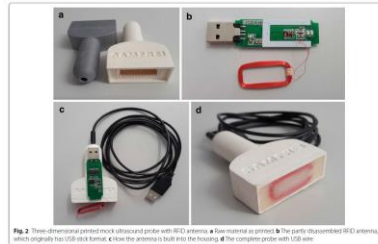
These dimensions printed mock ultrasound probe with RFID antenna. b) Two material as printed. c) The partly disassembled RFID antenna, which originally has USB stick format, d) how the antenna is built into the housing. e) The complete probe with USB cable.
